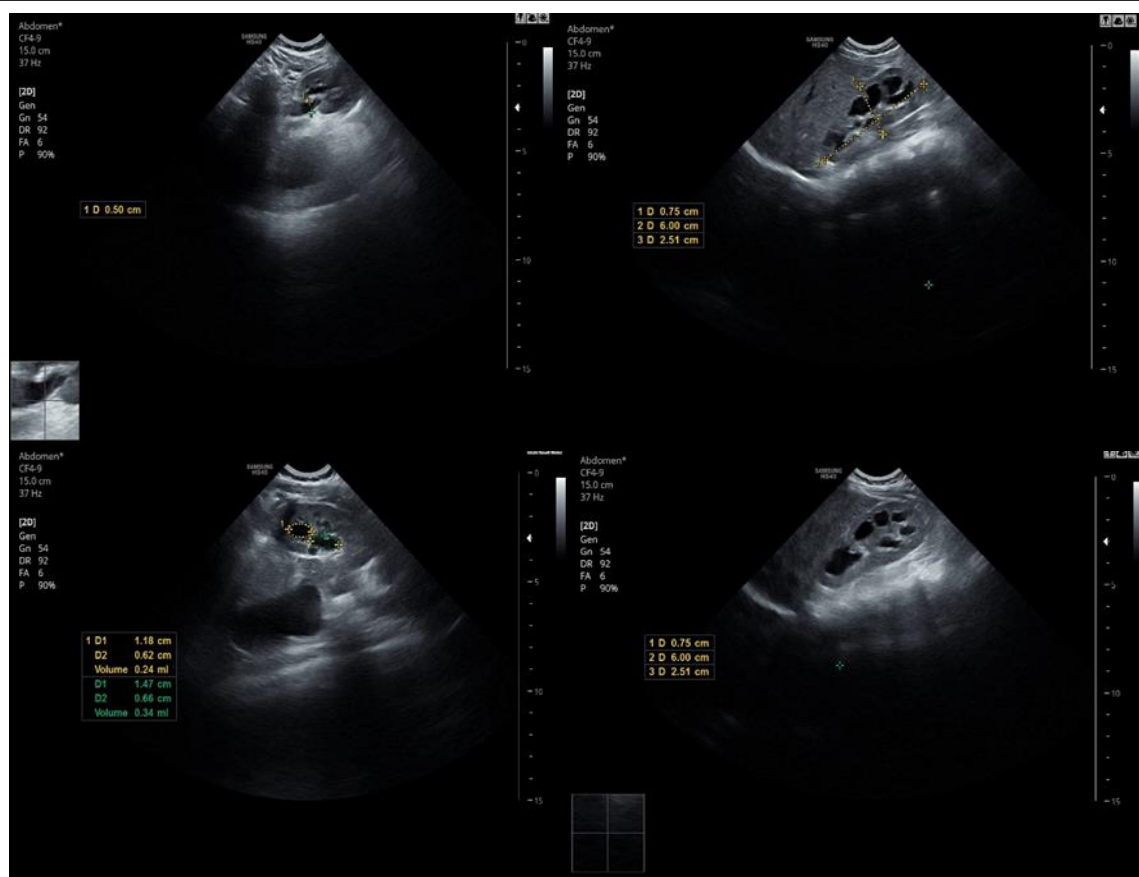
V.A., ultrasound imaging in evolution, with decreased urinary stasis (images from the archive of the Clinic).
